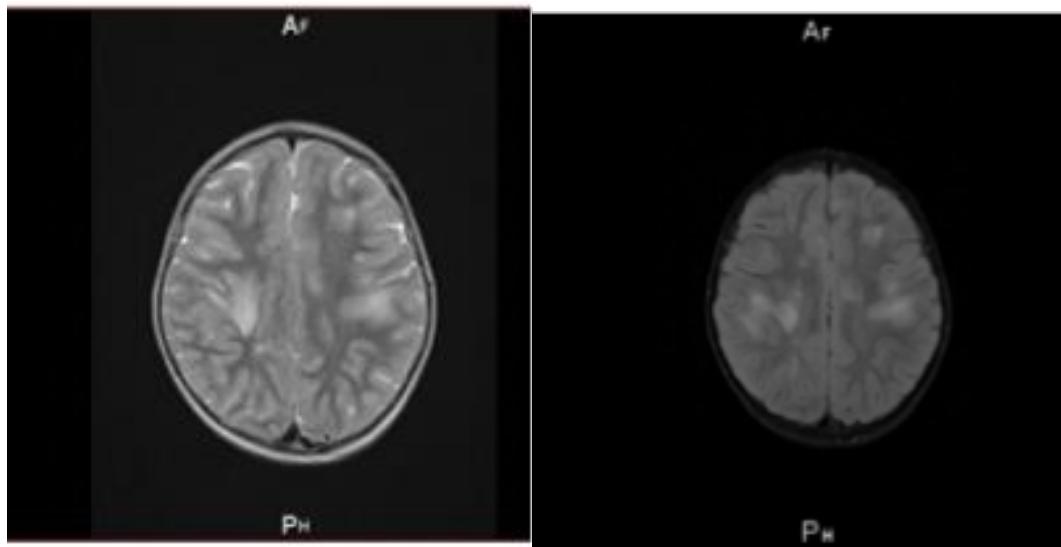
and Figure 2: Patient's brain MRI T2 weighted image sample
